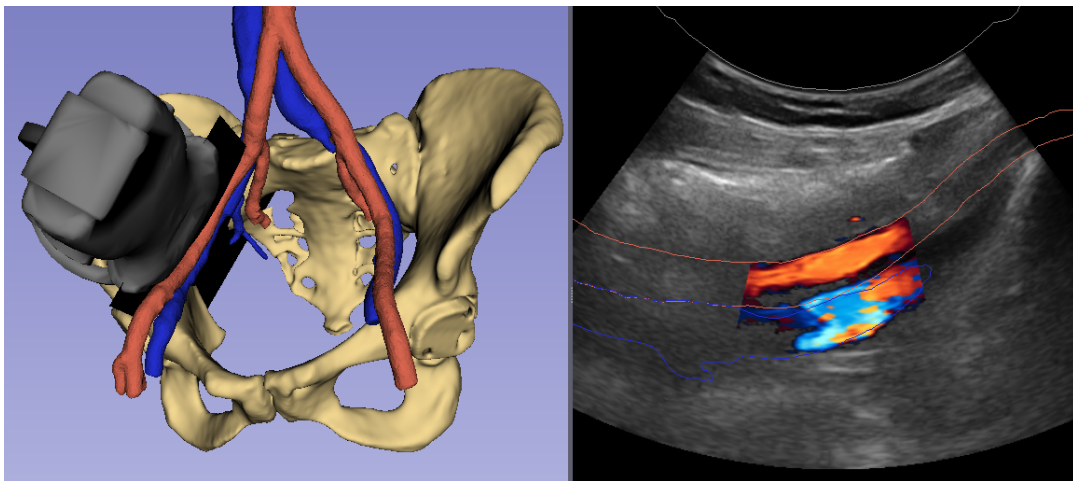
Tracked US interface in 3D Slicer with Doppler function enabled. A 3D model of the Clarius US device (grey), pelvic bone (beige), arteries (red) and veins (blue) is visualized on the left with the 2D Doppler US image on the right.
